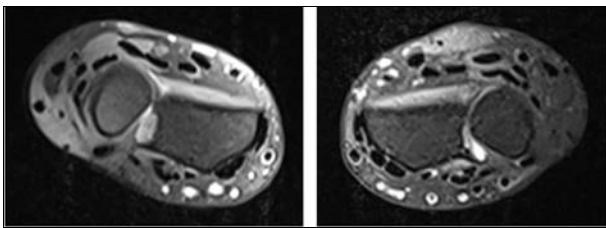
Axial MRI coupes of the forearm. Left is the normal variation of the PL in the patients left arm. The right image is the reversed PL in patient's right arm
